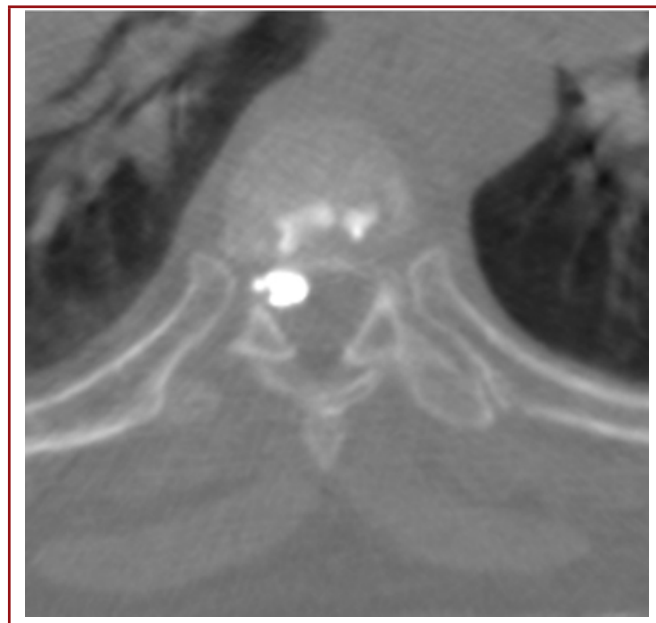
Axial CT scan passing through the T8-T9 disc space. The cement can be seen in the right side of the epidural space, in the right T7-T8 intervertebral foramen and in the T7-T8 disc space.
